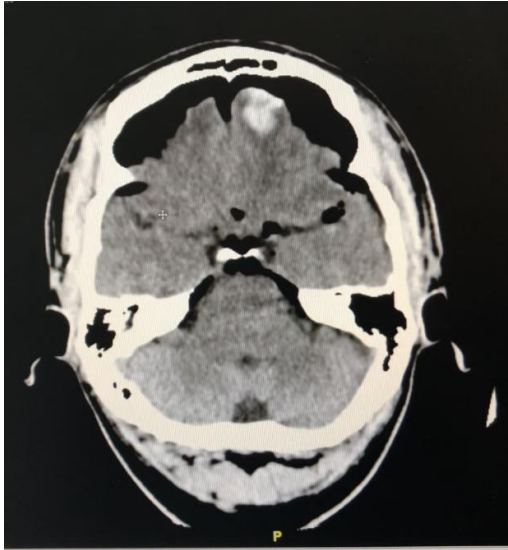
Parenchymal view of plain CT image show "Mount Fuji sign" with left frontal intraparenchymal bleed that separate the subdural layer.
